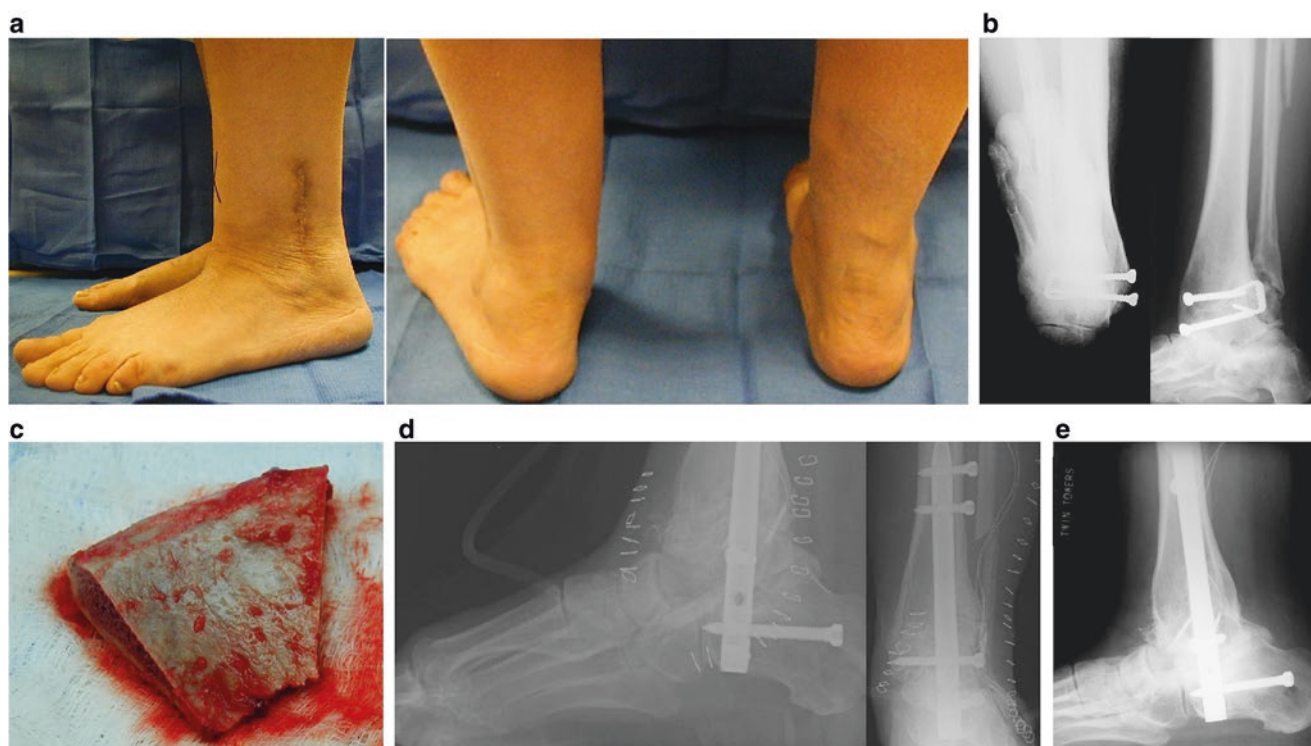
(a) Nonunion following ankle arthrodesis with residual valgus deformity (b) Radiographs demonstrating nonunion. (c) Structural graft harvested from iliac crest. (d) Conversion into tibiototalcalcaneal
